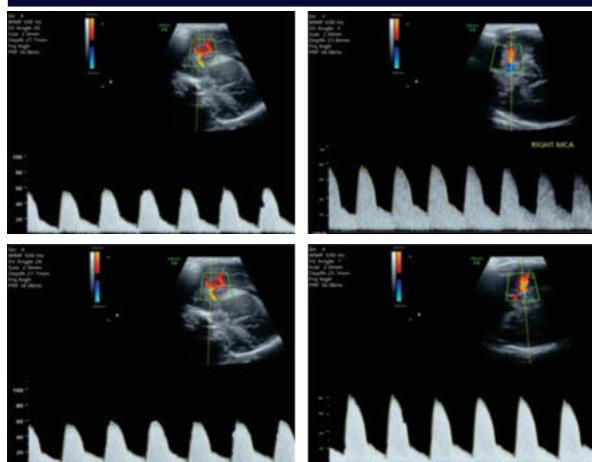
A day 1 neonate male born through Lower segment caesarean section (LSCS) developed bilateral grade I germinal matrix bleed detected after serial NSG imaging on day 5 of life. Coronal plane images (a) depict grade I germinal matrix bleed in both the caudothalamic groove (b,c,d,e) depict the Doppler assessment of the anterior and middle cerebral arteries.
